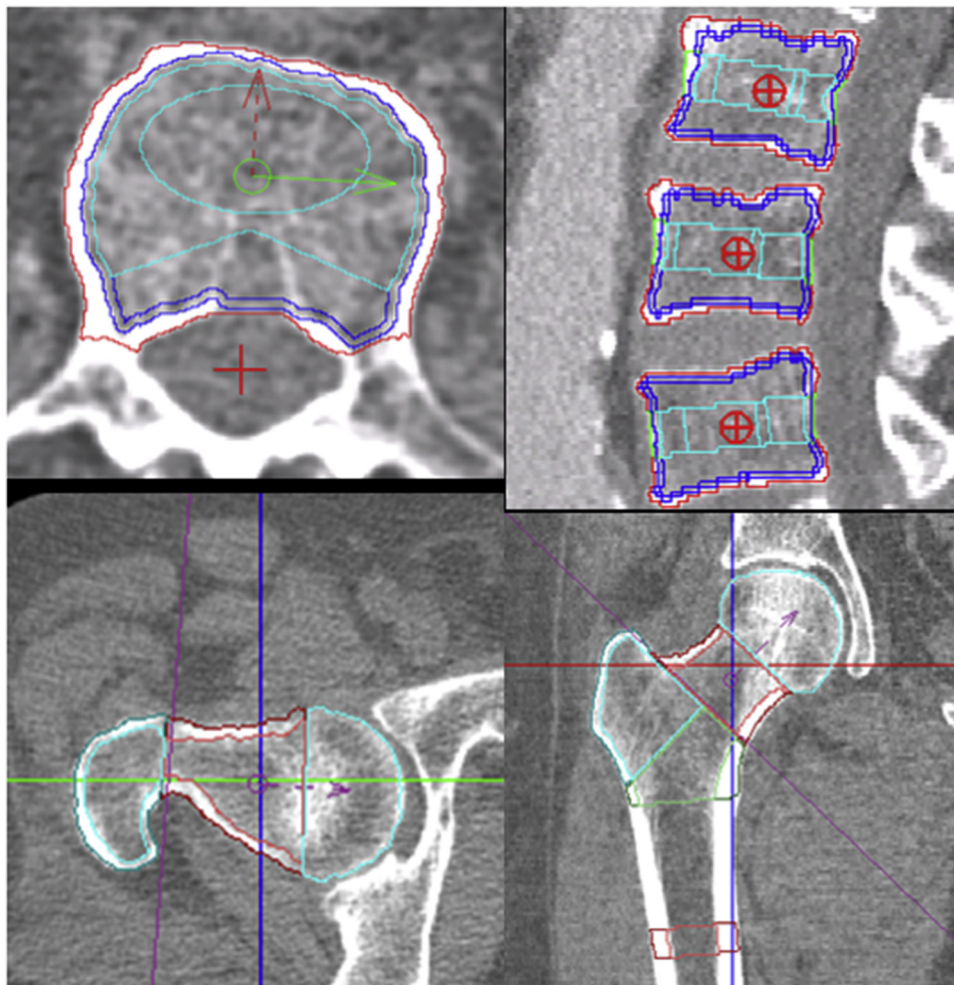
Advanced 3D quantitative computed tomography at spine and hip (slice thickness 1 mm, in-plane resolution 300 μm) to analyze regional bone mineral density and geometry such as cortical thickness. Left axial, right coronal multi-planar reformations of 3D data sets.
